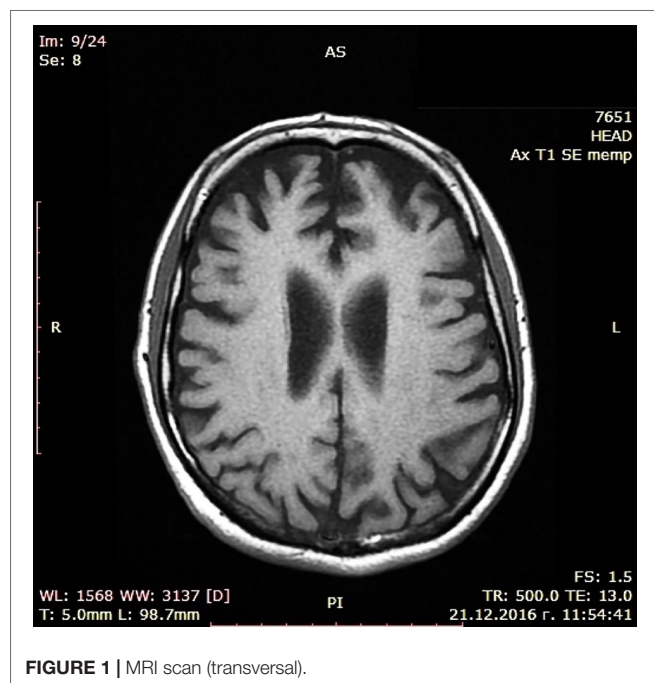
MRI scan (transversal).
